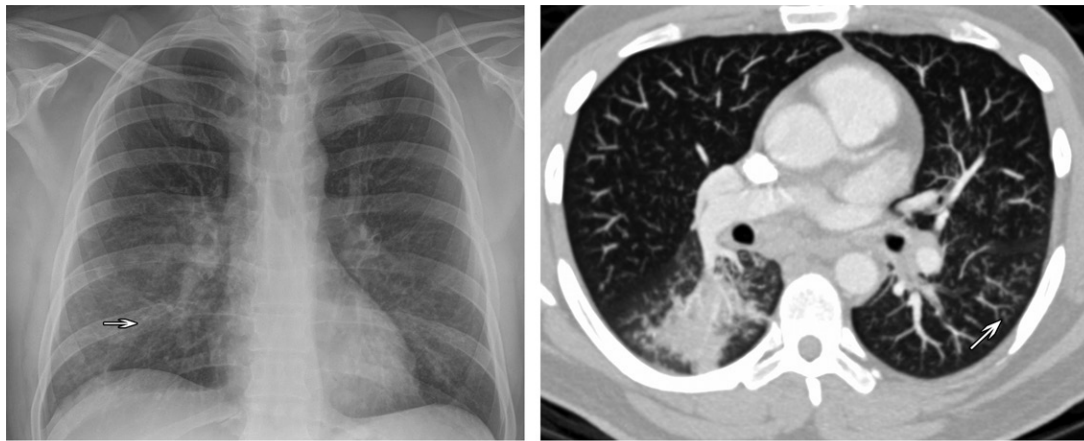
Parenchymal consolidation in a 46-year-old man with ulcerative colitis who presented with increased sputum production and fever for the preceding 10 days. (a) Posteroanterior chest radiograph shows a subtle patchy opacity (arrow) in the right lower lung, along with occasionally thickened central airways, which were greater on the right than the left. (b) Contrast-enhanced axial maximum intensity projection CT image shows consolidation in the superior segment of the right lower lobe and centrilobular nodules (arrow) in the left lower lobe. The results of blood and sputum cultures were unrevealing. The patient was treated for a community-acquired lower respiratory tract infection and pneumonia, and his condition improved clinically. Infection is more common in IBD patients compared with the general population.
